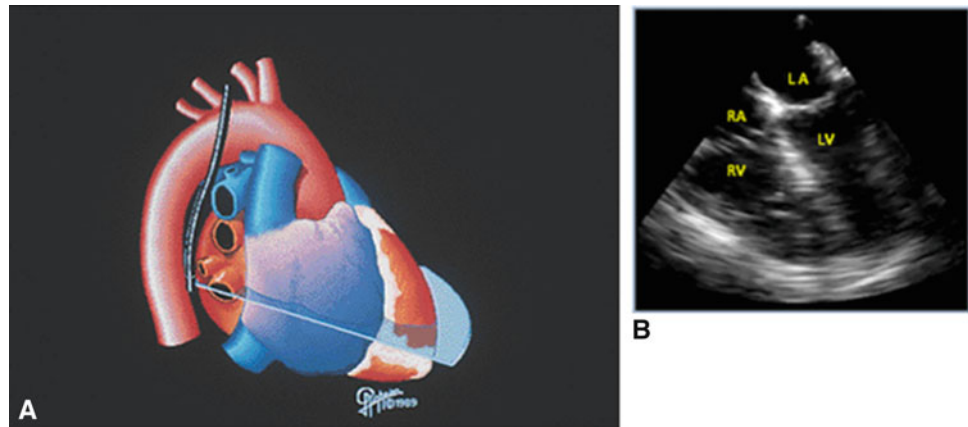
(a and b) Four chamber acoustic window as seen by the ultrasound probe. (a, From Nanda NC, Domanski MJ. Atlas of transesophageal echocardiography. Philadelphia: Lippincott Wolters Kluwer; 2007, with permission; b, from Hastings HM. Transesophageal echocardiography: guided hemodynamic assessment and management. ICU Director. 2012;3:38–41, with permission.)
